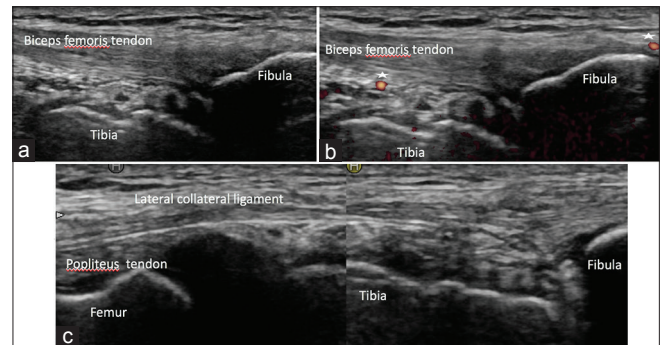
Ultrasound images showing long-axis view of the (a and b) biceps femoris tendon with (asterisks in image b) visible Doppler signals and (c) lateral collateral ligament
